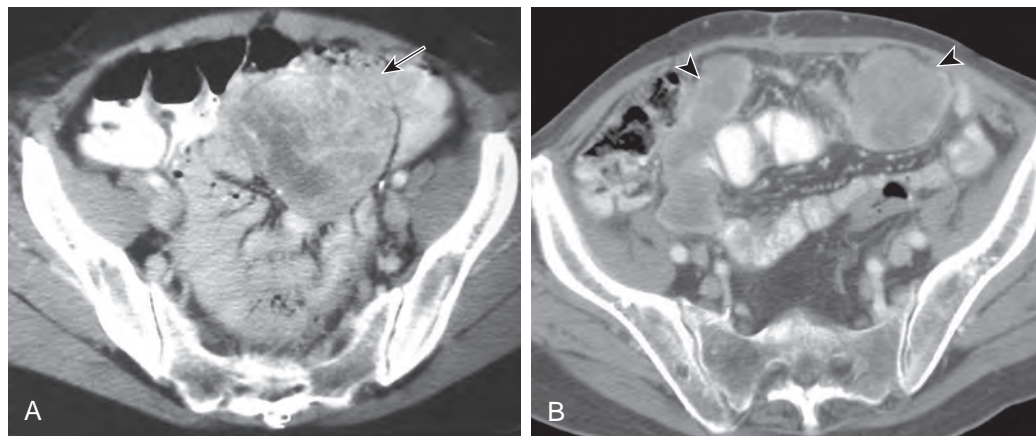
Assessing prognosis of GIST on CT. This 48-year-old woman had a GIST. A. At presentation, axial CT shows an 8-cm heterogeneously enhancing exoenteric mass (arrow) in the mid small bowel. The tumor was resected, and surgical pathology revealed a GIST with a high mitotic rate. B. Axial CT performed 4 months later shows interval growth of low-density mesenteric masses (arrowheads).
